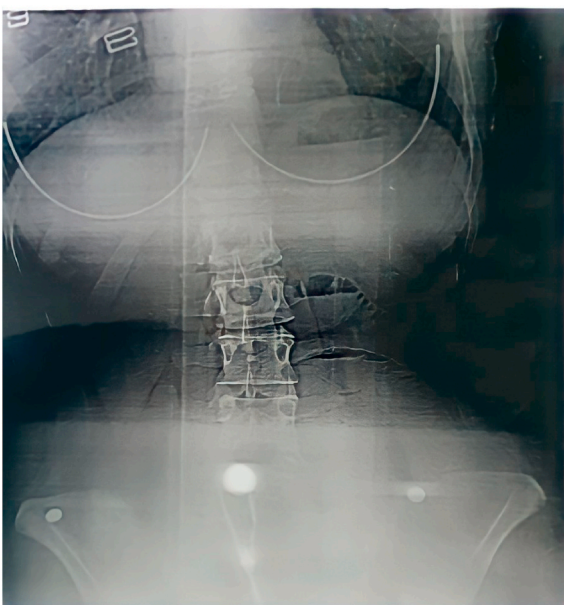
The abdominal x-ray showed small bowel air-fluid levels in the left side of the abdomen.
